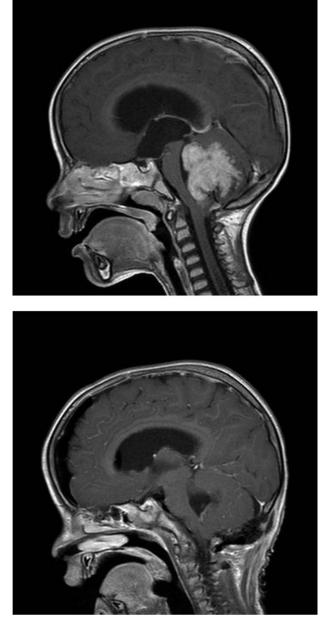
Sagittal T1-weighted brain MRI, after gadolium administration: a. posterior fossa medulloblastoma before surgery, demonstrating homogeneous enhancement, filling the fourth ventricle and causing obstructive hydrocephalus. b. post-operative image 24 hours after surgery, confirming gross total resection of the tumor.
